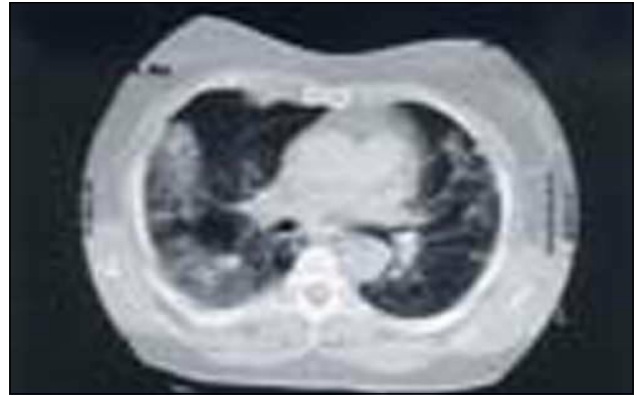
High resolution computed tomography showing bilateral pleural based infiltrate typical of bronchiolitis obliterans organizing pneumonia.
